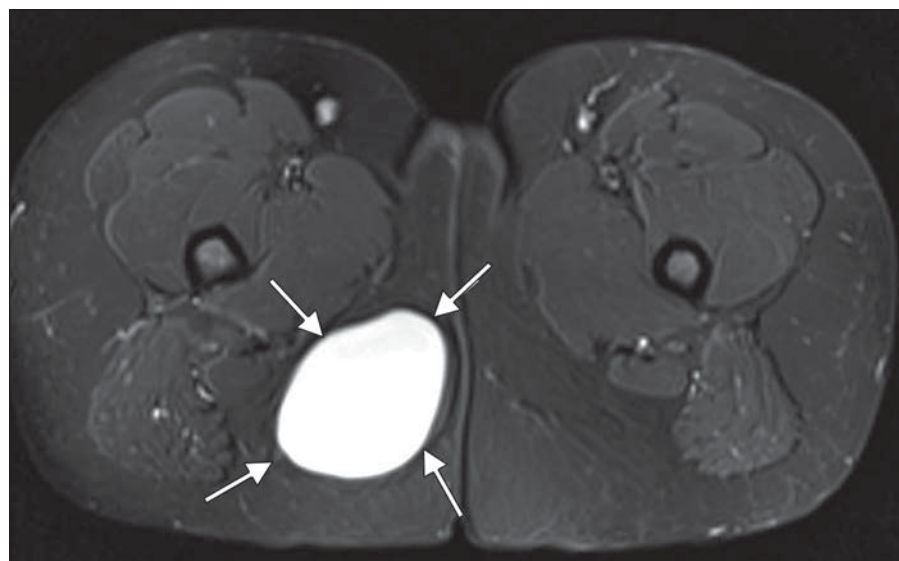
15-year-old girl with dermoid cyst presenting as slow-growing painless lump in right gluteal region. Axial T2-weighted MR image with fat saturation shows large homogeneously hyperintense oval lesion (arrows) suggesting cystic nature. Note lack of septations.
